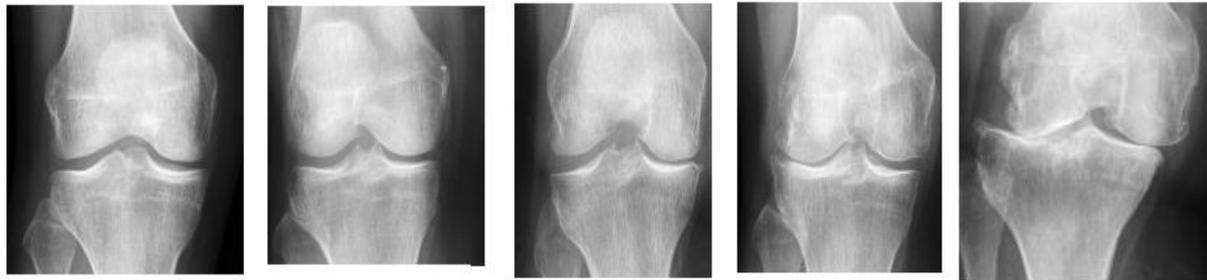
Examples of X-ray scans for each phase of osteoarthritis (OA) - (KL-0, KL-1, KL-2, KL-3, KL-4)
